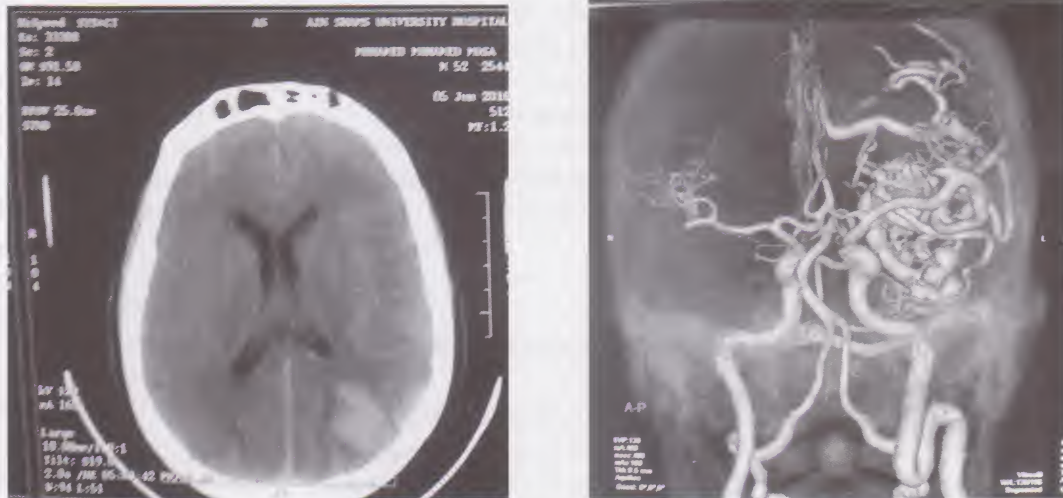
CT scan (left image) showing a left occipital hematoma.
